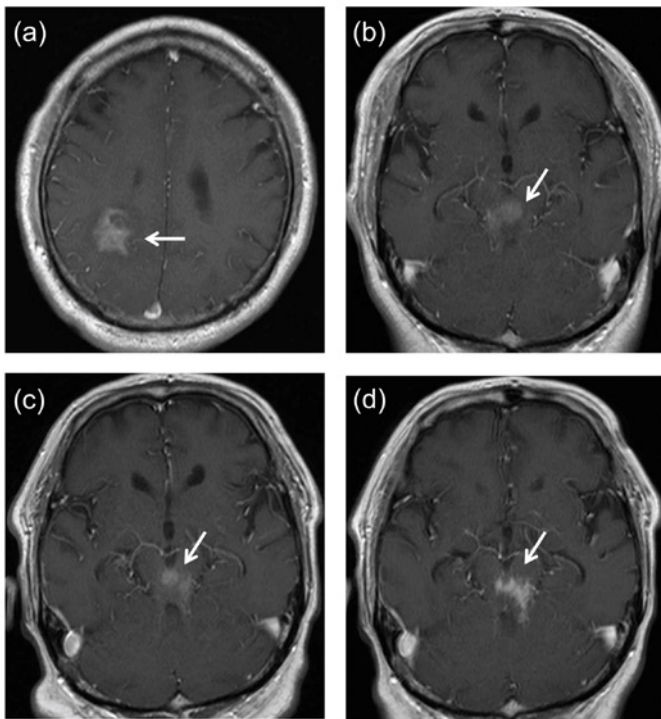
Magnetic resonance imaging of the brain at initial diagnosis and after treatment: Gadolinium-enhanced T1 weighted images reveal a high-intensity lesion in the parietal lobe (a) and brain stem (b). The lesion improved after ibrutinib monotherapy (c). Six weeks after administration of ibrutinib, the lesion worsened (d).
